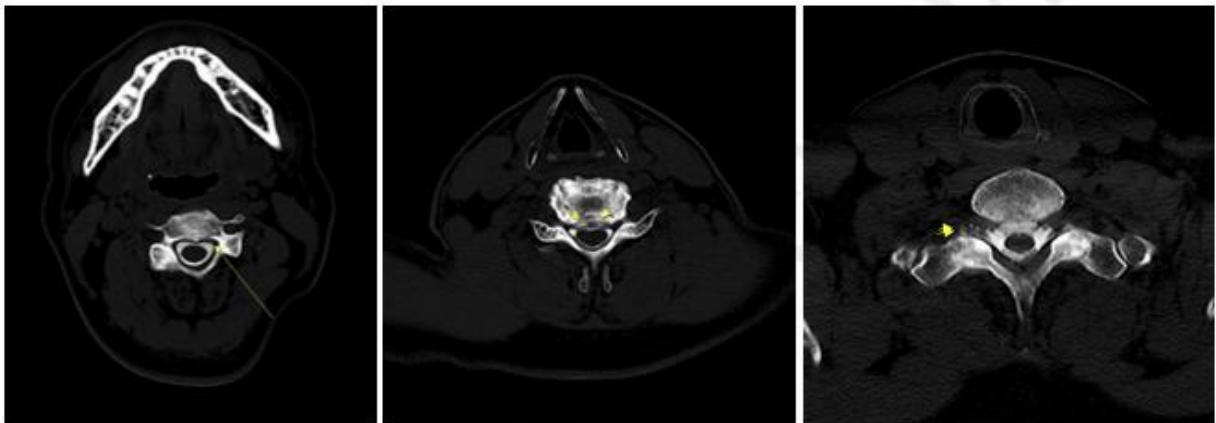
axial CT myelography images, sequentially at the level of C2/3, C5/6, and C7/T1. Yellow arrow indicates contrast leakage at epidural space.
